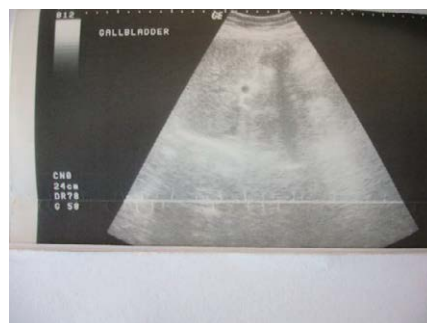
Ultrasound report-gall bladder.
